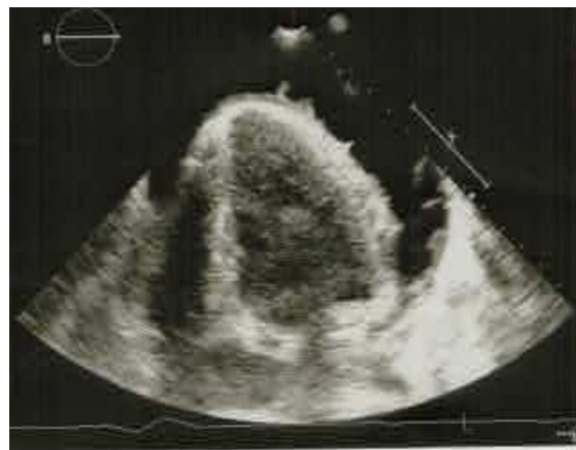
Echocardiogram showed a circumferential pericardial effusion with initial collapse of the right ventricular free wall.
